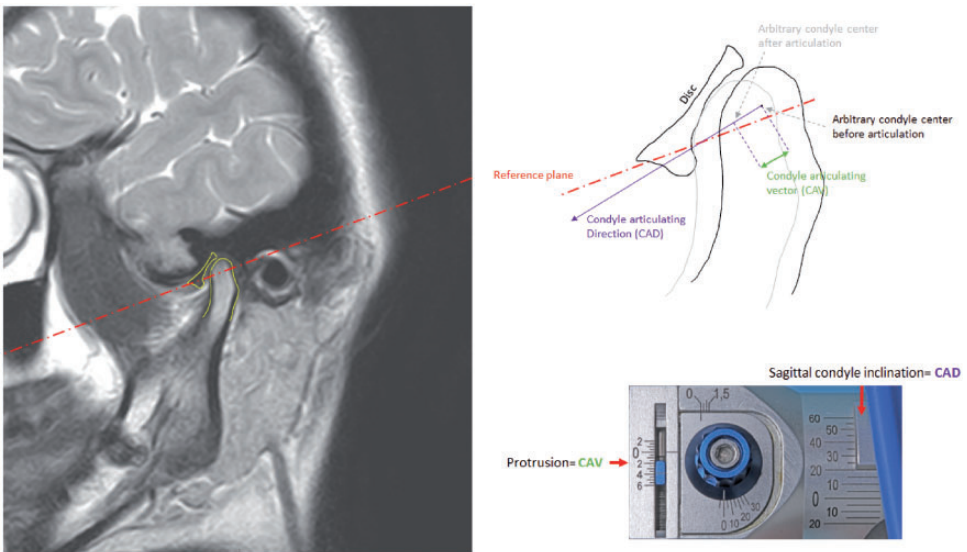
Measurements were based on the magnetic resonance image (oblique sagittal plane), and adjustments on the articulator were made accordingly. The lateral adjustment was made by a similar method using the coronal plane image.
